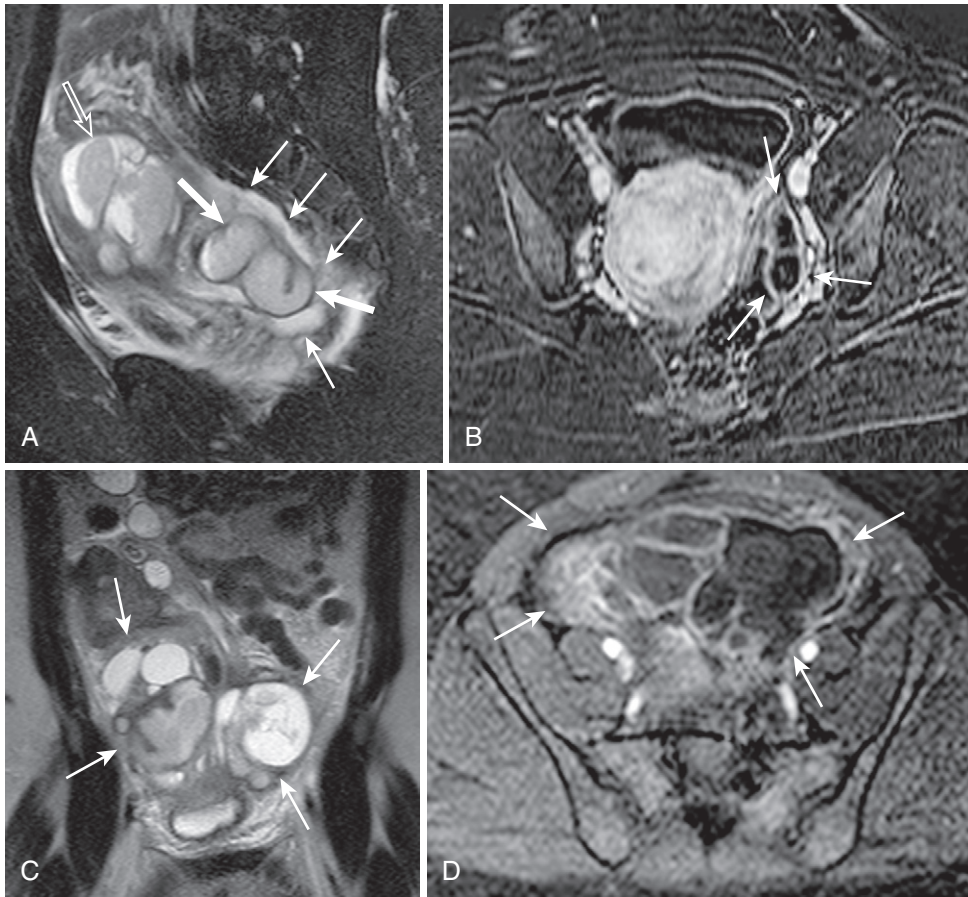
Pyosalpinx. A, Sagittal T2-weighted fat-suppressed image shows edema (*thin arrows*) surrounding a dilated fallopian tube (*thick arrows*), which indicates inflammation, further supported by the complex, heterogeneous fluid collection (*open arrow*). B, The subtracted image after gadolinium administration reveals a greater degree of wall thickening and enhancement (*arrows*) than would be expected in the absence of inflammation. Coronal T2-weighted (C) and axial enhanced T1-weighted fat-suppressed (D) images disclose the full extent of the TOA (*arrows*).
